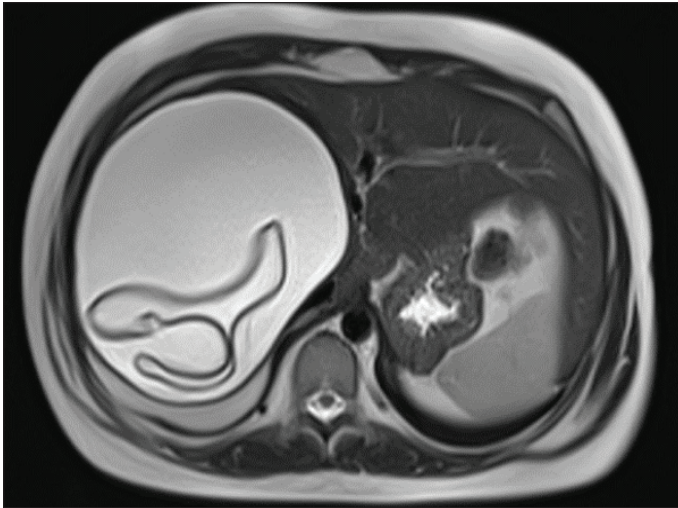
Axial T2-weighted MR image.
